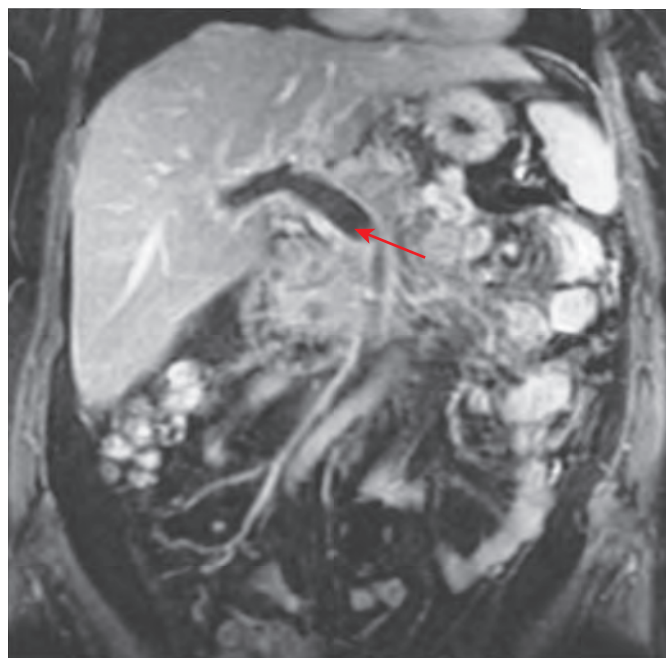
Portal vein thrombosis: MRI findings. Coronal image shows thrombus (arrow) in the main portal vein.
